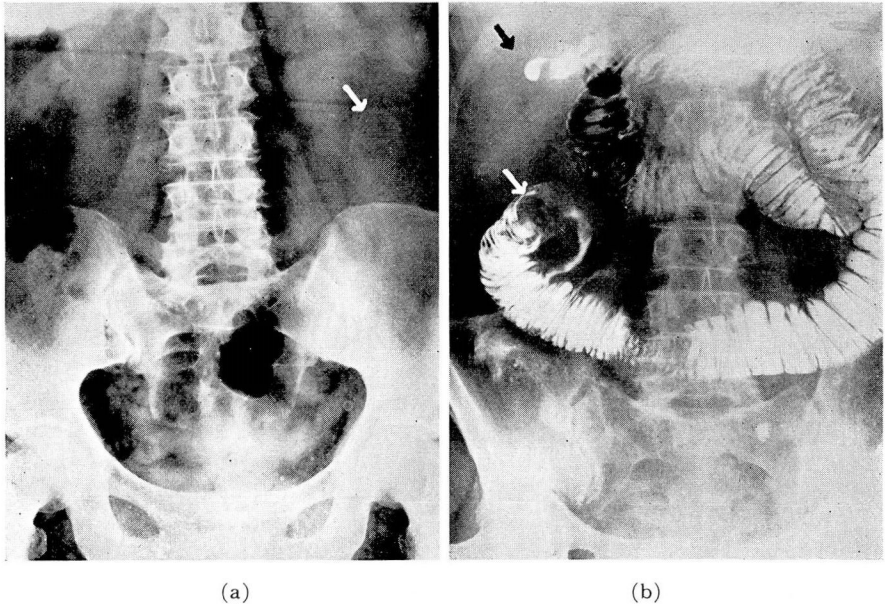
(a) Plain film of abdomen. Faintly visualized "signet-ring" shadow in left upper abdomen suggestive of gallstone; (b) obstruction of jejunum with dilatation proximal to site of obstruction. Large gallstone shown (white arrow). Black arrow designates barium in hepatic radicles.
